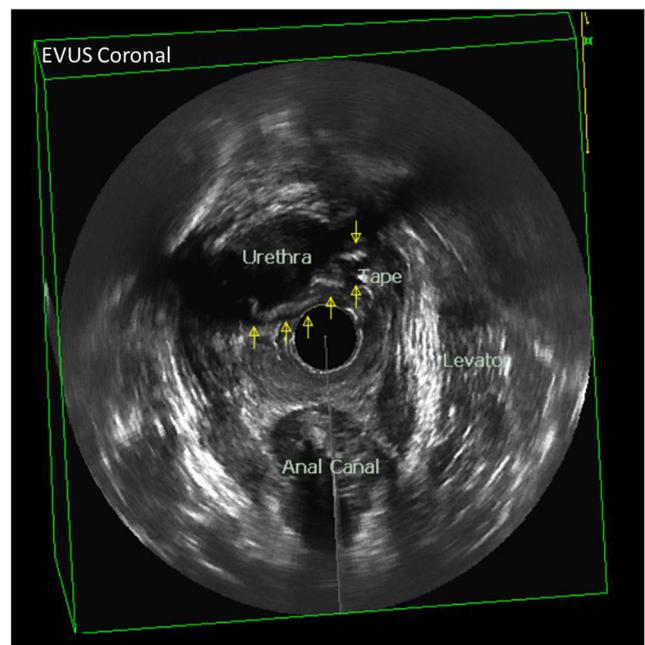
Curled mid-urethral sling (MUS). Endovaginal ultrasound demonstrating a MUS both situated far from the urethral lumen and folded, suggesting laxity. This patient presented with persisting stress urinary incontinence
